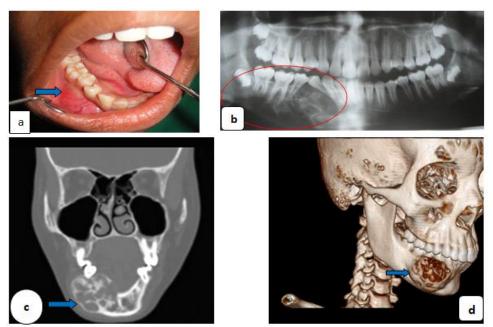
Clinically showing buccolingual expansion b) Orthopantamogram showing well defined solitary lesion with displaced44 and 45. c) Computed tomography coronal cut showing large lesion in the right mandibular region. d) Three dimensional facial cuts showing buccal cortical perforation in right posterior mandibular region
